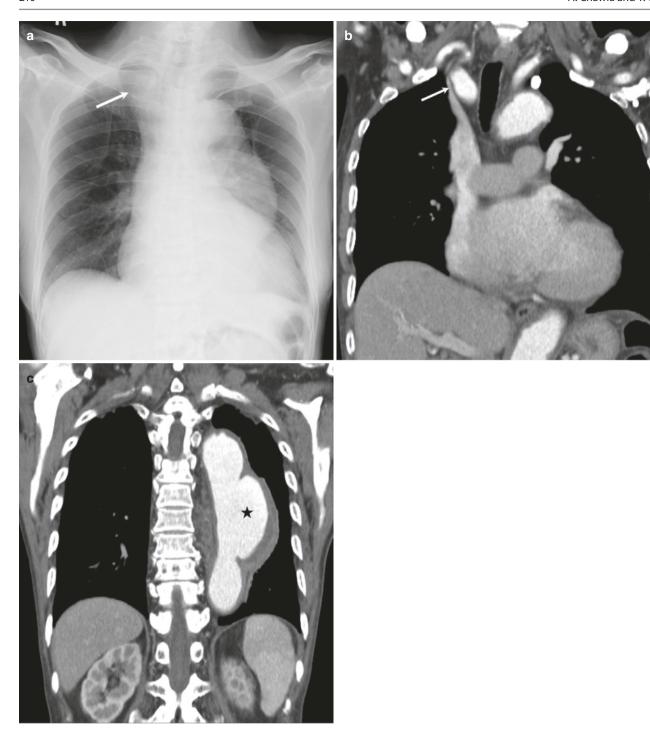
74-year-old woman presented to the emergency department with acute chest pain from descending thoracic aortic aneurysm. (a) Frontal radiograph shows a left hilar mass not silhouetting the left heart border but obscuring the descending aorta. "Hilum overlay" sign is present. Imaging features are consistent
